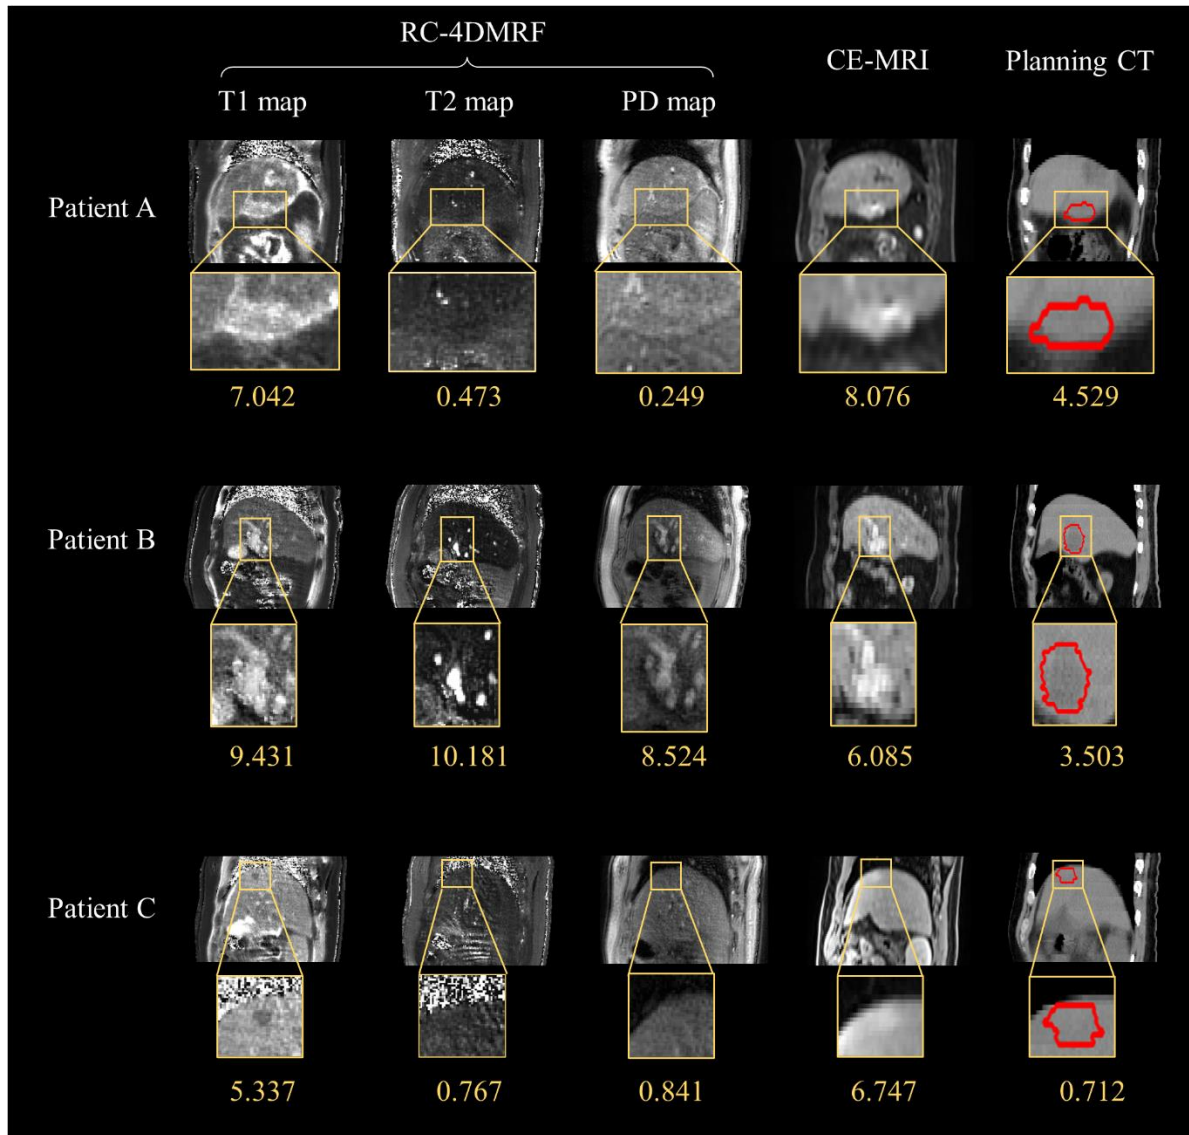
Comparison of respiratory-correlated four-dimensional magnetic resonance fingerprinting (RC-4DMRF) tissue maps with clinical scans (contrast-enhanced magnetic resonance imaging (CE-MRI) and planning computed tomography (CT) scans). The tumor regions are expanded in the yellow boxes, and the gross target volumes are contoured by the red lines in the CT images. The tumor contrast-to-noise ratio is presented under each yellow box.
